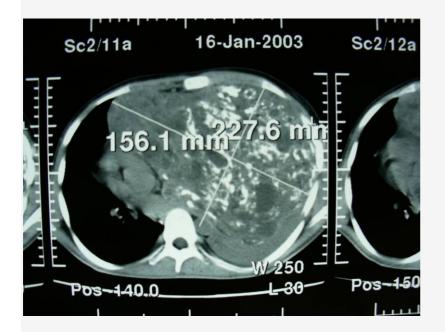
CT scan showed giant mediastinal tumor deviated the heart, right lung and fully compressed the left lung. Bones, calcified focci and cysts were visible in the tumor.
